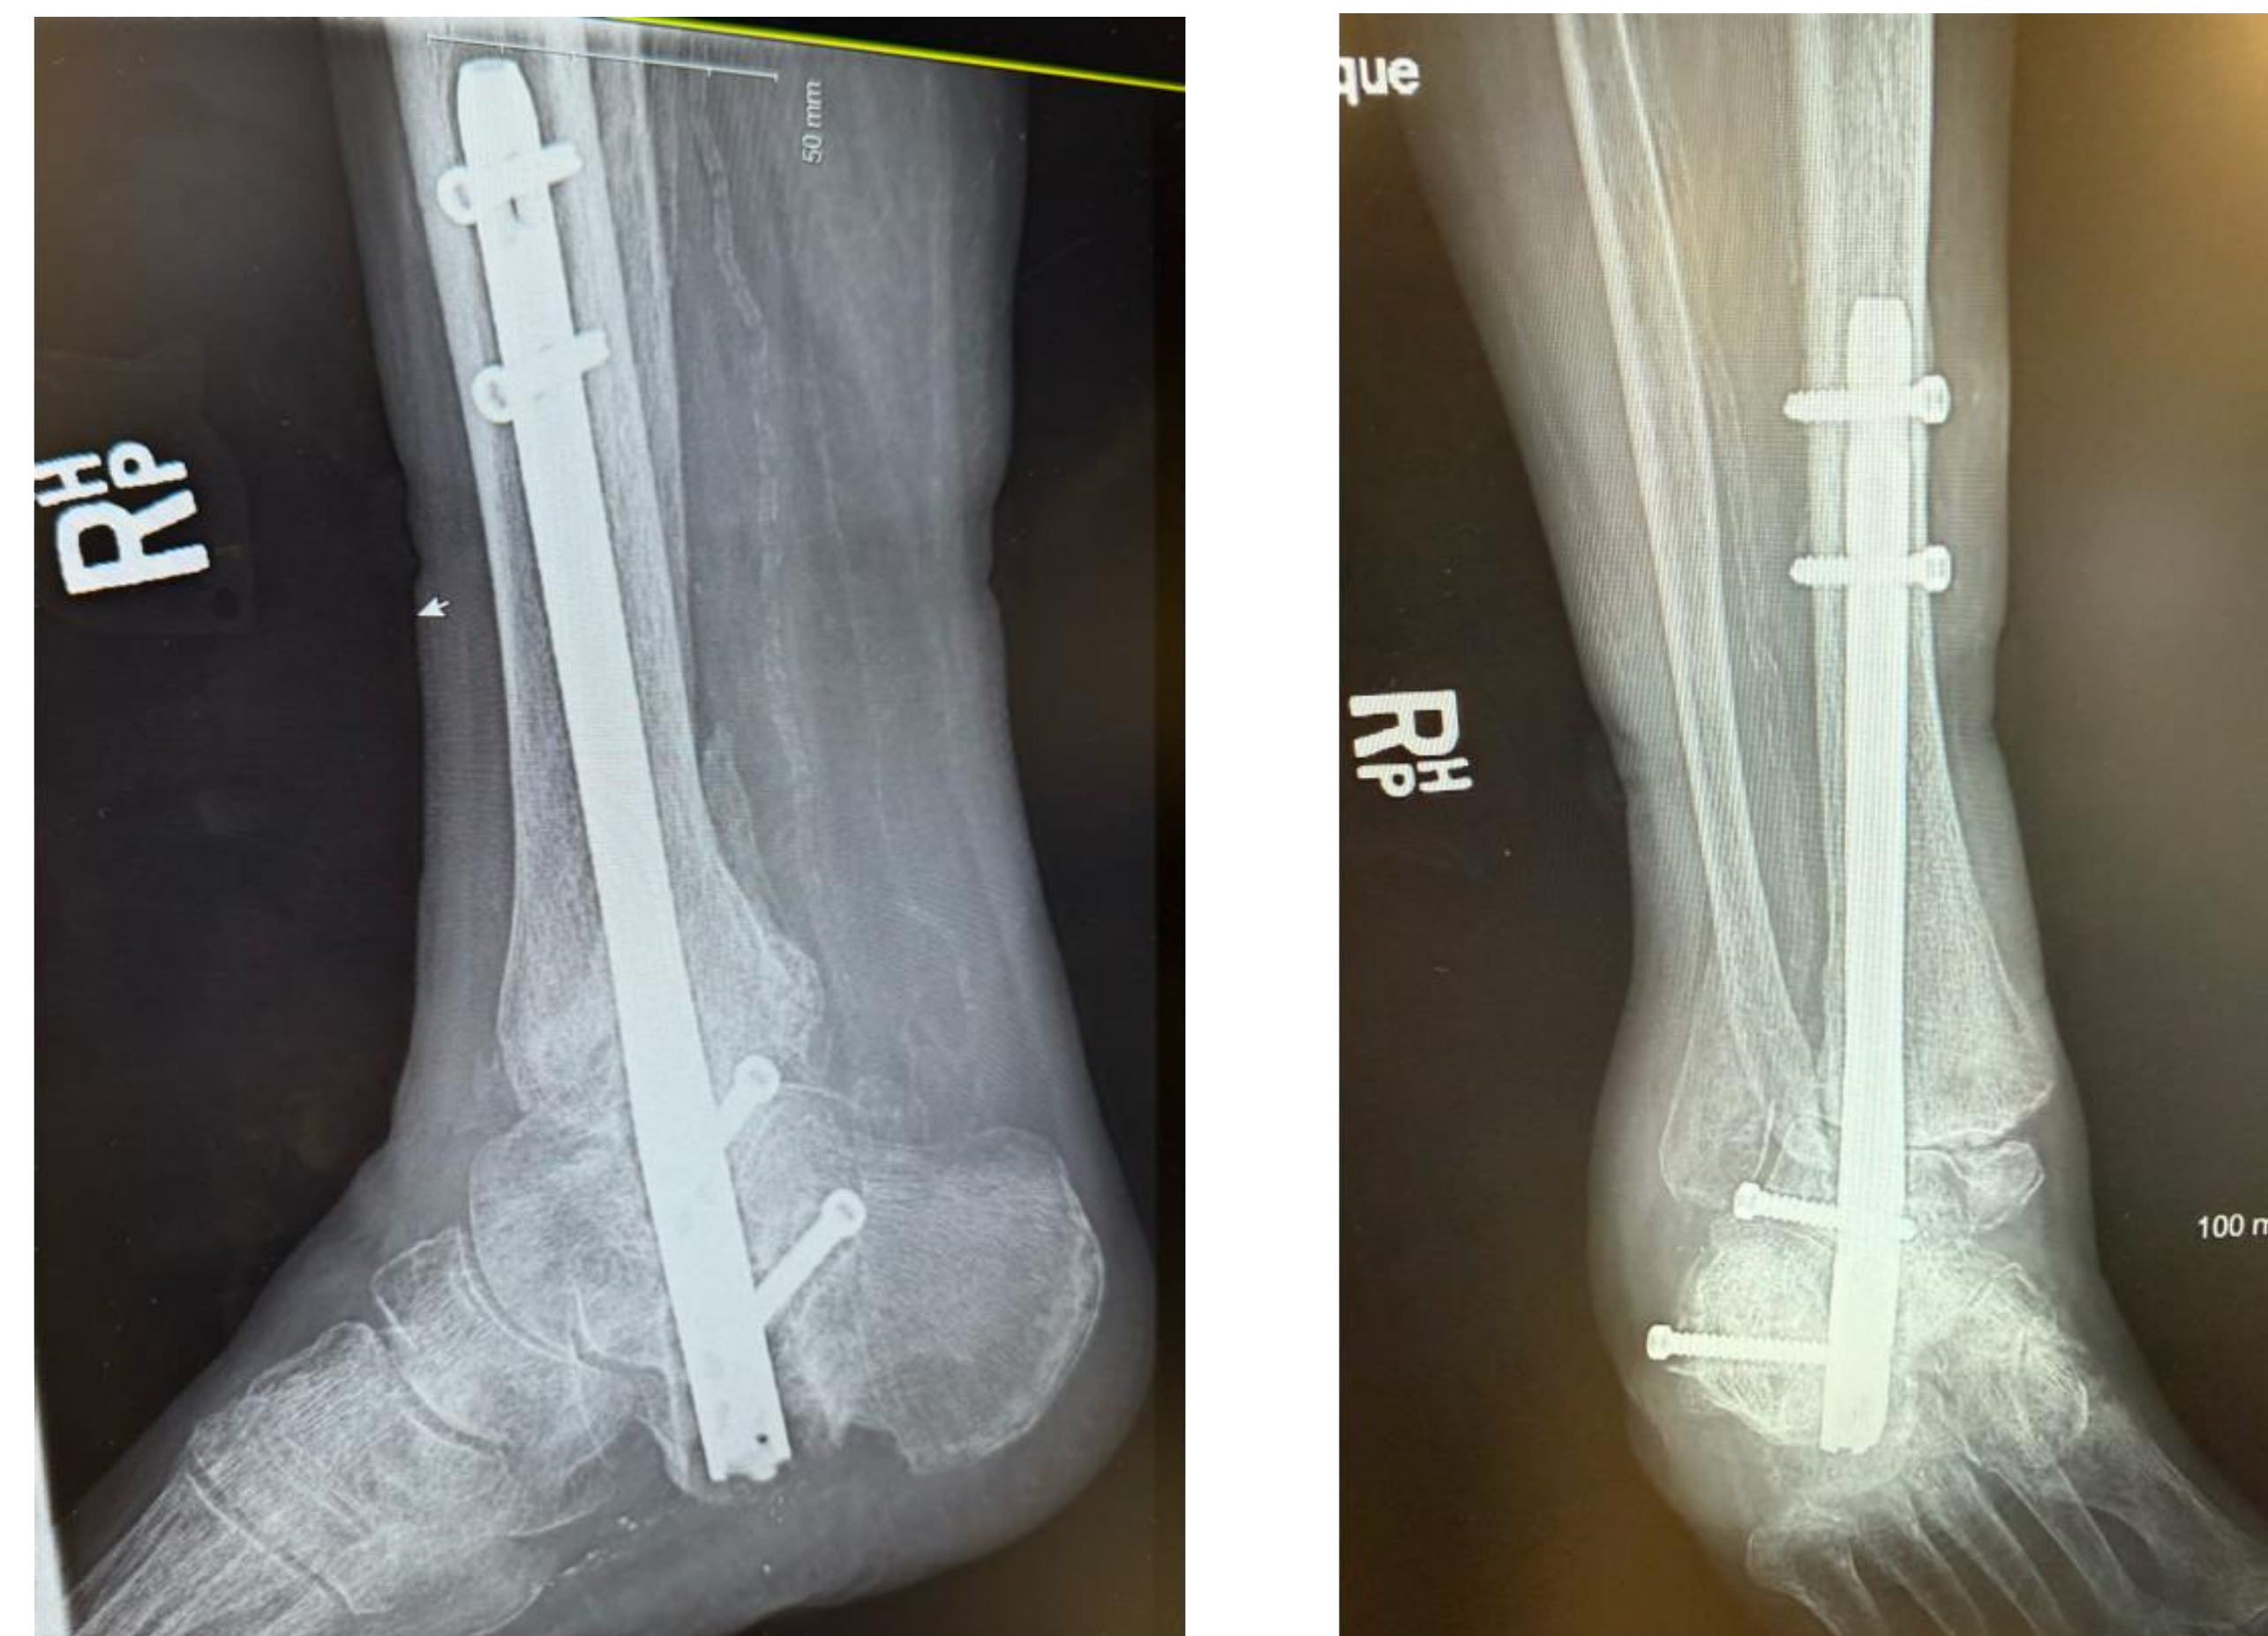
Preoperative Lateral and Mortise view X-rays of the right ankle
